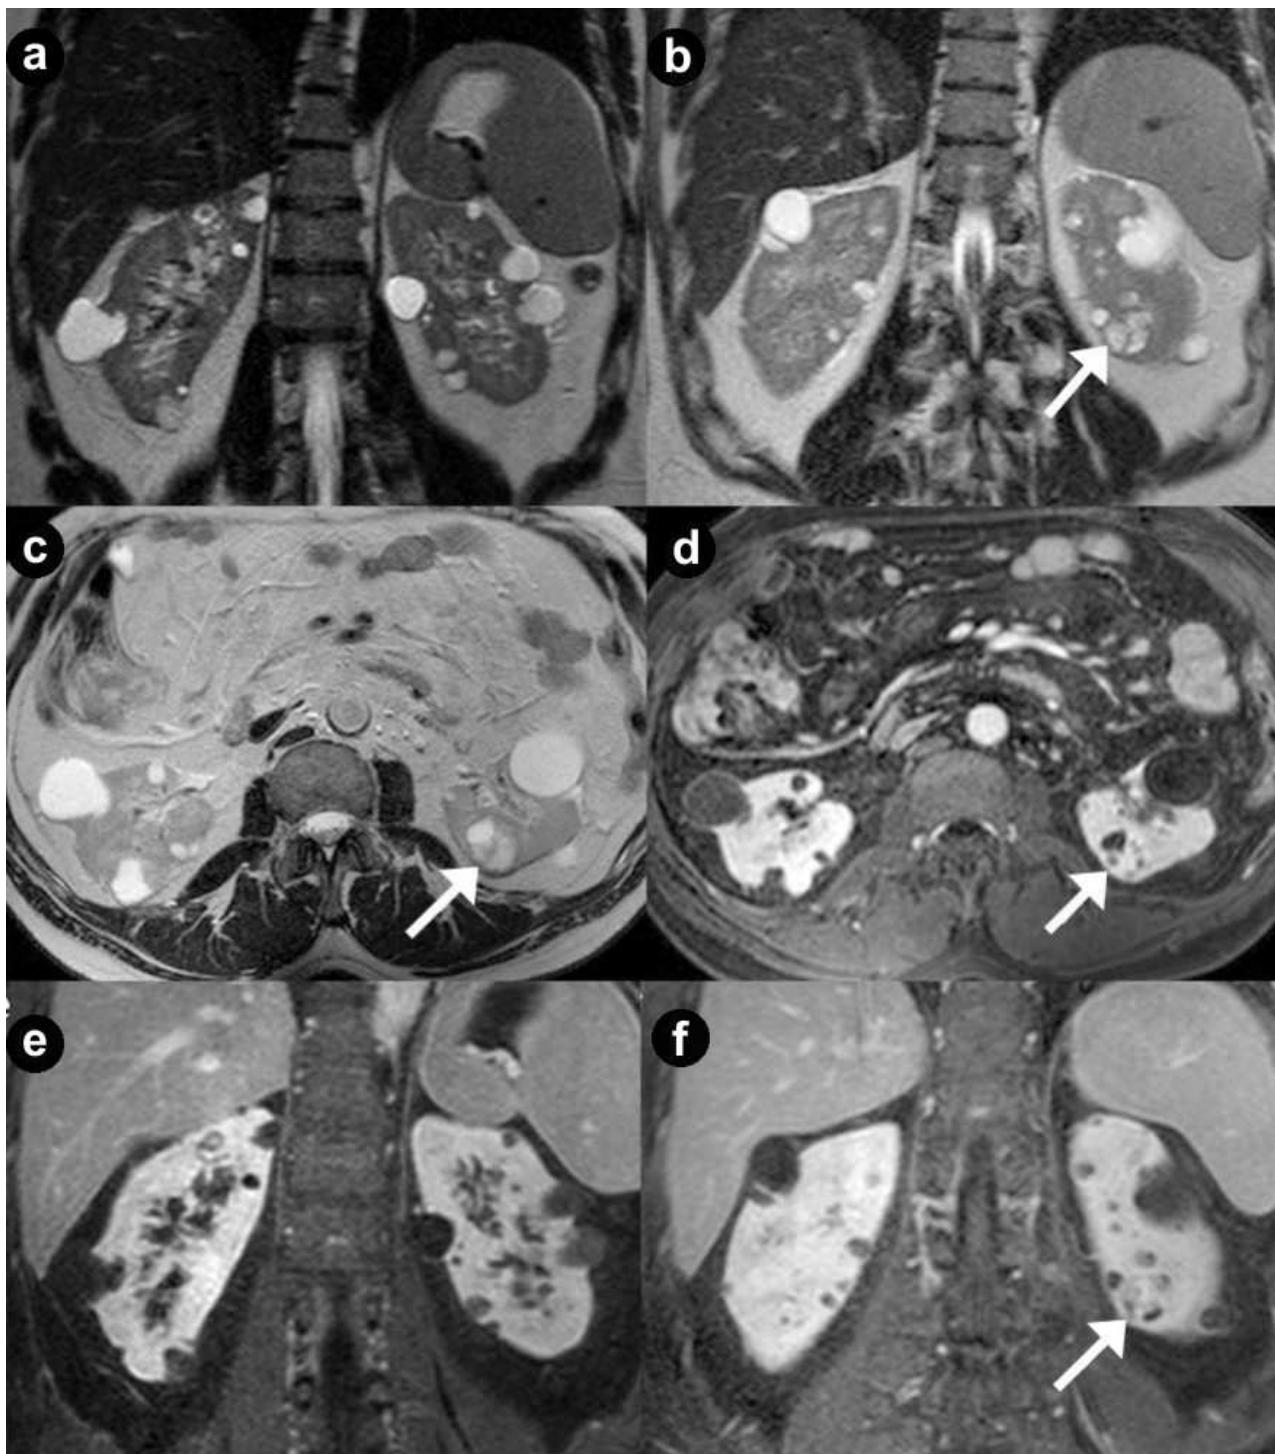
Renal cysts and cystic renal cell carcinoma. A 43-year-old man with VHL disease. Coronal (a, b.) and axial (c.) T2-weighted MR images; axial (d.) and coronal (e, f.) 3D volumetric gradient-echo T1-weighted fat suppressed images after intravenous contrast medium administration during arterial (d, e.) and venous (f.) phases of contrastographic dynamic study.
